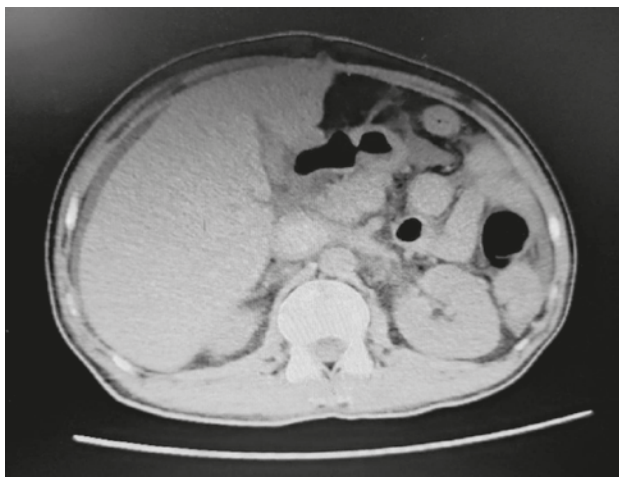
Post operative CT Abdomen on 35 th POD showing IVC thrombus and ascites
